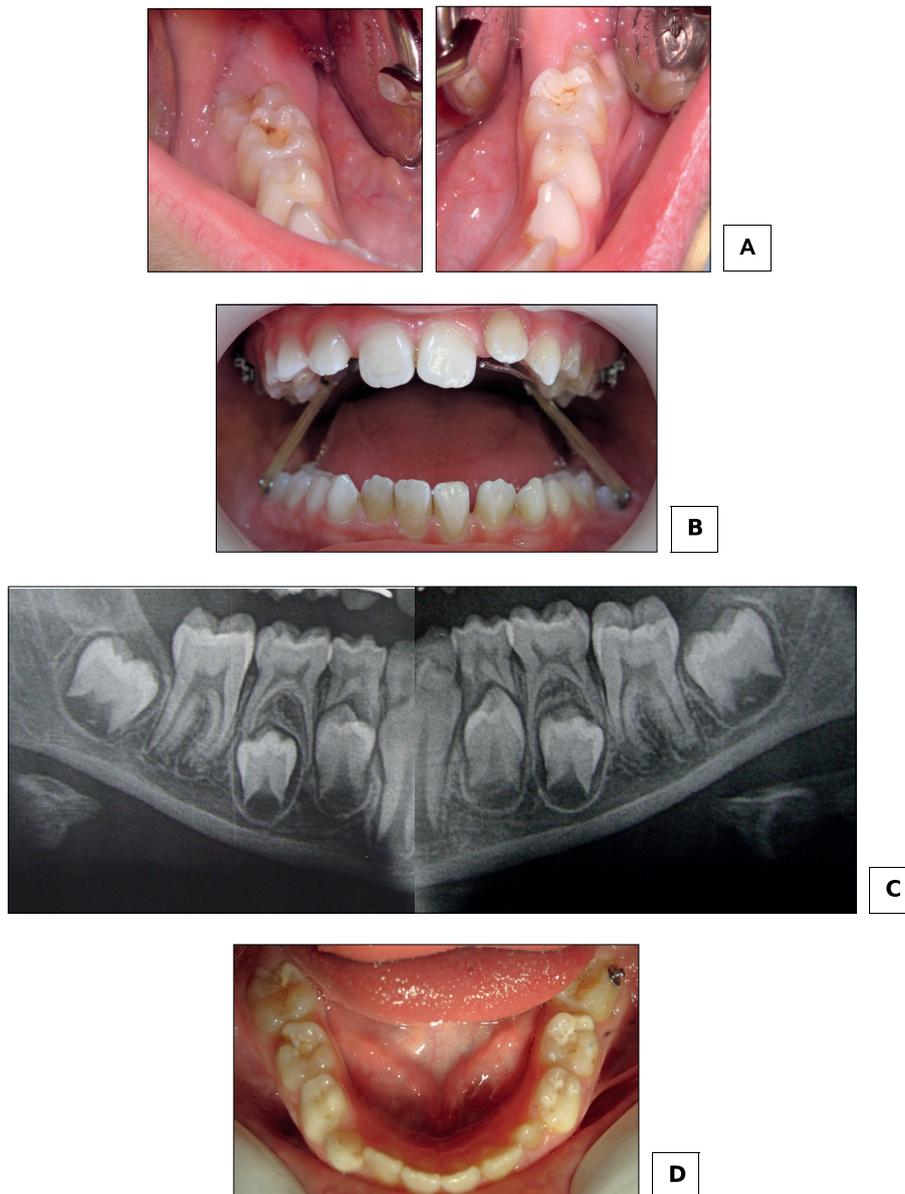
Case 1: follow-up. A: intraoral view 2 months later, partial eruption of 36 and 46. B: orthodontic appliance, quad-helix and traction elastics. C: panoramic X-ray, 10 months later, demonstrating a full bony healing and a quite normal eruption pattern. D: intraoral view, 18 months later, physiological position of 36 and 46.
